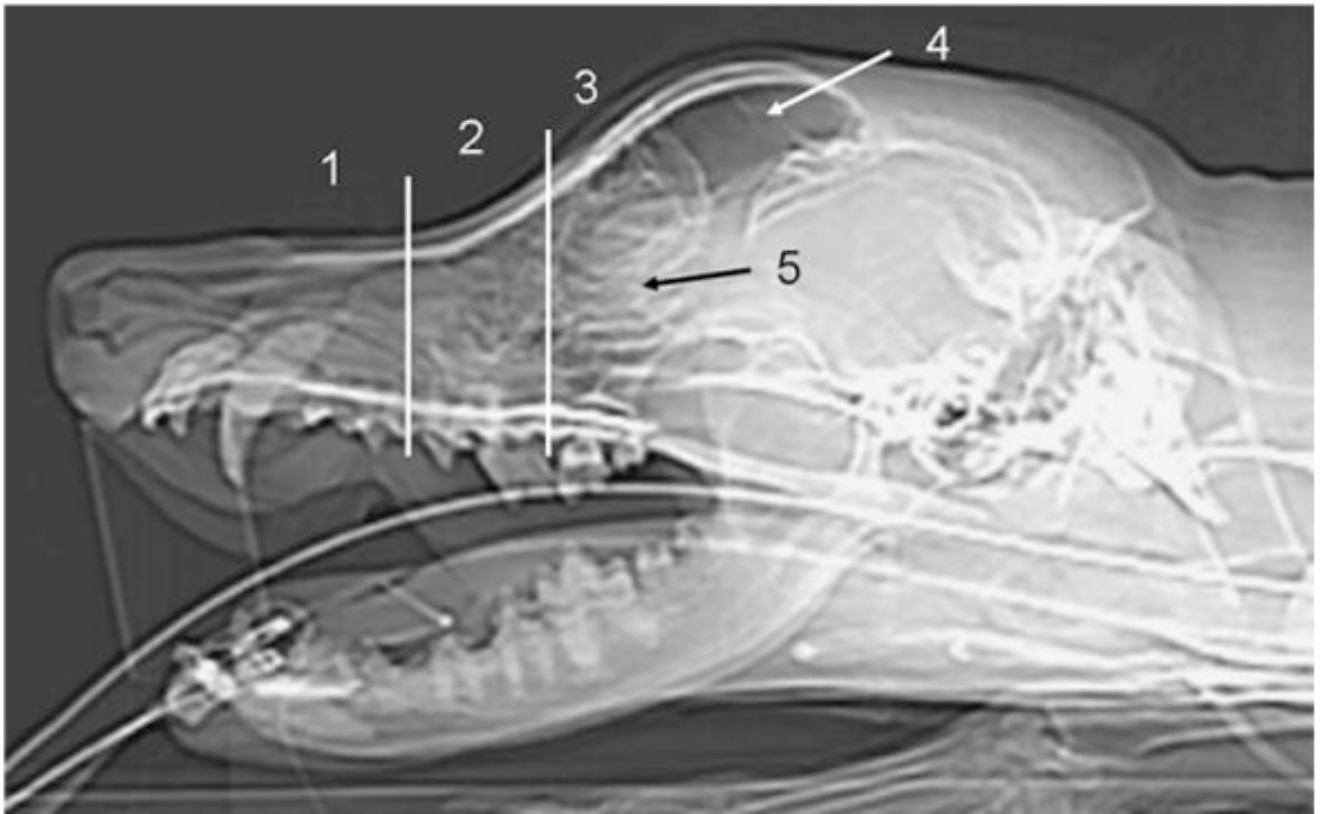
Evaluated areas displayed on a lateral computed tomography scout image: nasal cavity (1) rostral to maxillary recess, (2) at the level of the maxillary recess, (3) at the level of the ethmoid turbinates caudal to the maxillary recess, (4) frontal sinus, (5) cribriform plate. The transverse lines indicate the rostral and caudal borders of the maxillary recess
